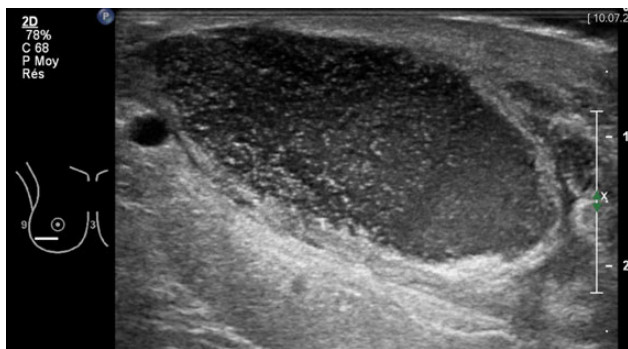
Right breast ultrasonography (US) showing encapsulated purulent collection (4 × 4 × 15 cm) in correspondence of the lower lateral quadrant, 7 weeks after breast reduction surgery. Abscess drainage was performed under US guidance.
